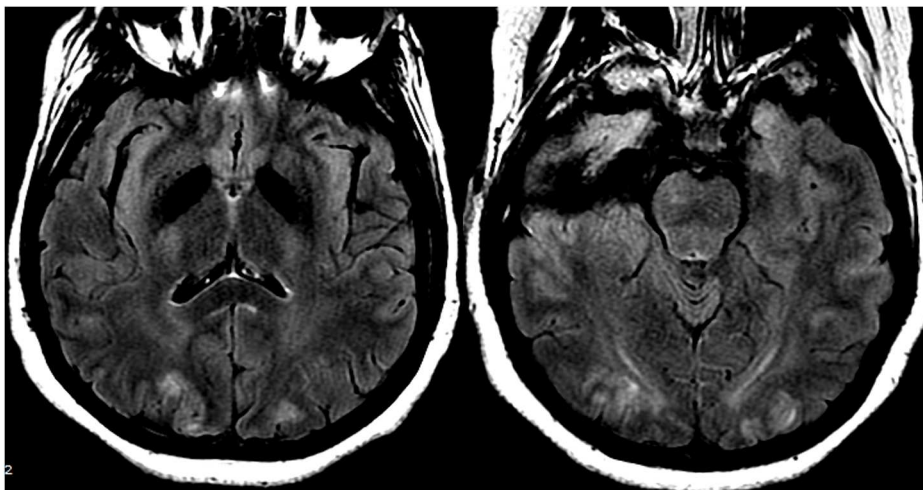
Patient with eclampsia and presenting with seizure. Axial T2-FLAIR images demonstrate symmetric signal abnormality in the bilateral occipital lobes.
